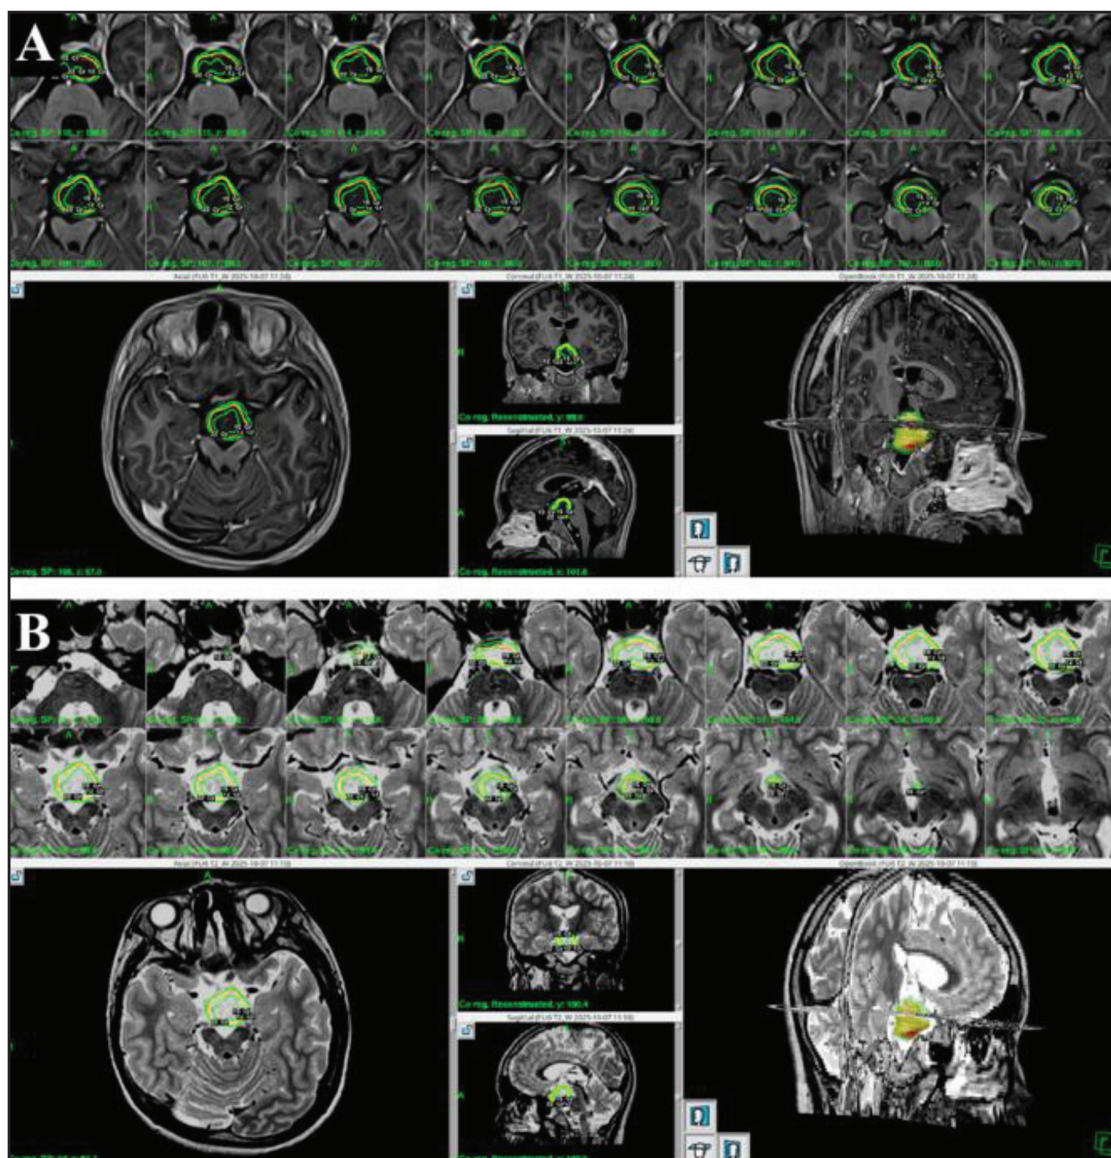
Follow-up MRI of Case 3 at 6 months after GKRS. Axial T1-weighted (A) and T2-weighted (B) images demonstrating transient lesion enlargement to 8.602 cm³ following treatment. Radiological enlargement was not accompanied by sustained clinical improvement and was interpreted as a post-radiosurgical treatment-related change.
